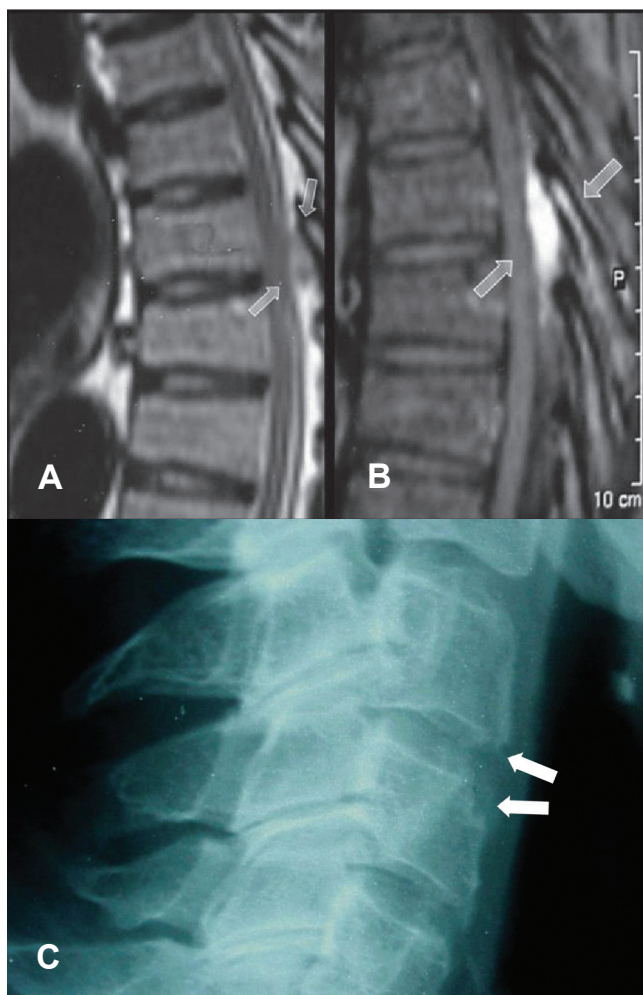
(A and B) MRI of thoracic spine on lateral view. Note the presence of a low signal lesion in T1 indicated by the arrows (A) before and (B) after contrast administration, with a homogeneous enhancement. (from: Hasegawa EM, Goldenstein-Schainberg C, Fuller R. Rev Bras Reumatol. 2007;47(4):300-2). (C) Lateral radiography of cervical spine in a patient with chronic tophaceous gout. The arrows show erosions in the anterior aspects of the vertebral bodies.
